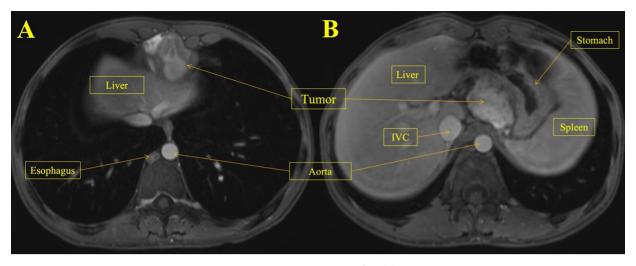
MRI imaging showed two heterogeneous, highly attenuated masses. The first (A), a midline mass within the cardiophrenic/retrosternal area extending into the abdomen and abutting the left lobe of the liver. The second (B), an intraabdominal mass located in the lesser sac, deep to the gastrohepatic ligament and impinging on the gastro-oesophageal junction near the spleen and inferior vena cava (IVC).
